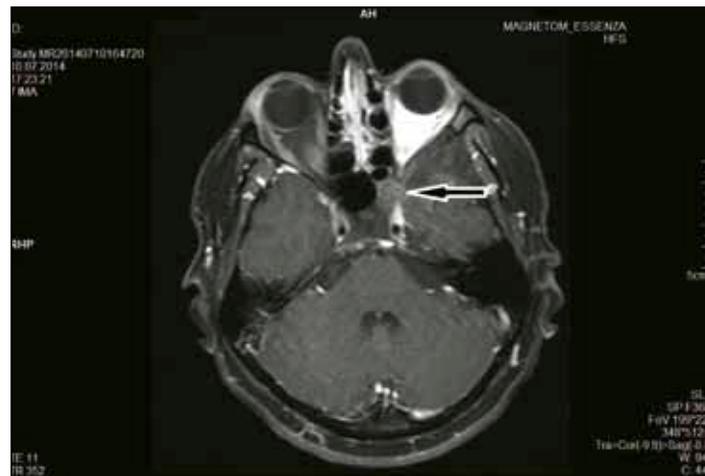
Cranial MRI, axial scan, showing: fibrous dysplasia of the greater and lesser wings of the left sphenoid sinus that diminished the left orbital volume, which hallmark the lateral rectus muscle. Retrobulbar orbital left edema.
